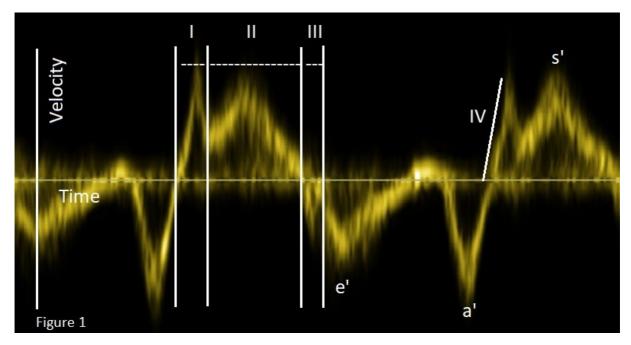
Velocities and cardiac time intervals obtained by pulsed tissue Doppler trace at the tricuspid annulus on the right ventricular free wall; I) isovolumic contraction time; II) ejection time; III) isovolumic relaxation time; IV) isovolumic acceleration; a' — late diastolic tricuspid annular velocity; e' — early diastolic tricuspid annular velocity; s' — peak systolic tricuspid annular velocity
